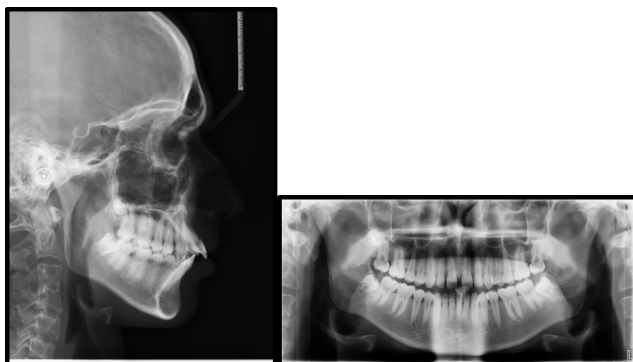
Pre Treatment X-Rays
